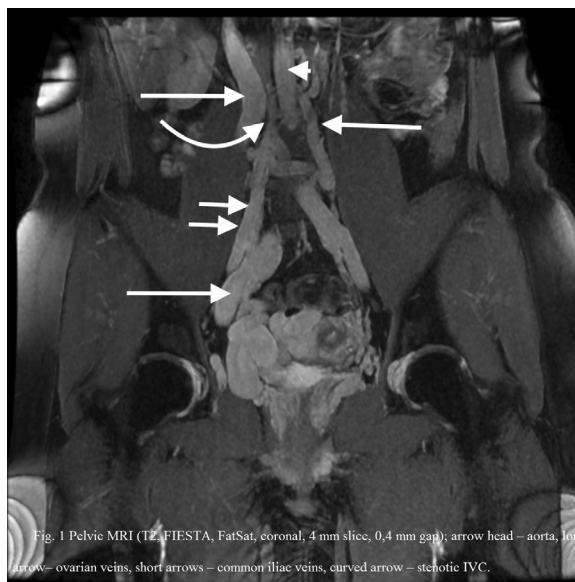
Pelvic MRI (T2, FIESTA, FatSat, coronal, 4 mm slice, 0.4 mm gap); arrowhead — aorta; long arrow — ovarian veins; short arrows — common iliac veins; curved arrow — stenotic IVC
